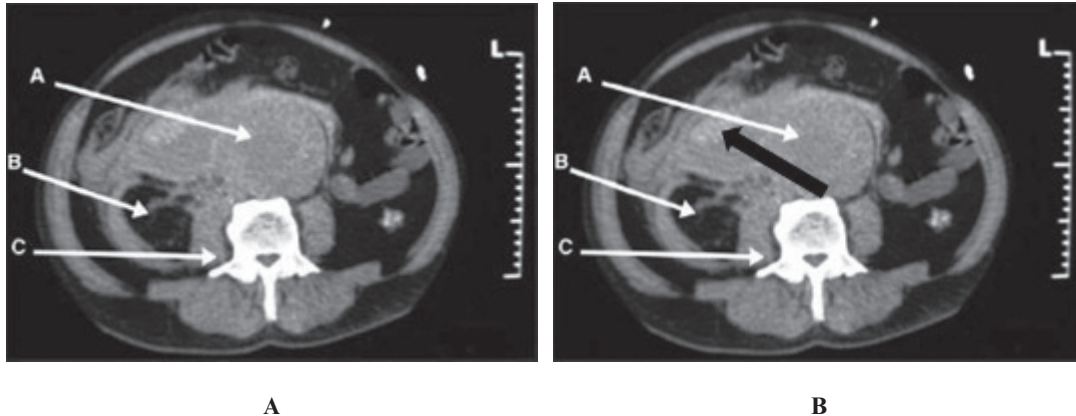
A, An unenhanced axial computed tomographic (CT) image of the abdomen as originally published. The original caption read, “A CT scan showing a large 9-cm infrarenal aortic aneurysm extensively leaking around the right kidney and psoas muscle. A = ruptured abdominal aortic aneurysm; B = right kidney; C = right psoas muscle surrounded by blood.” The kidney is not visible on this image, and the original arrow “B” is pointing to perinephric fat. Reproduced with permission from Vaidyanathan et al.³ B, The same image with the sentinel clot material labeled (*black arrow*). Neglecting to highlight the sentinel clot was identified by radiologists as an error of description as this is a pertinent positive finding present on the image that helps identify the site of bleeding. Reviewing emergency physicians indicated that the labeling error affected educational value, whereas the description error could have affected clinical management and educational value. This image is summarized in Table 3, errors 7 and 8.
